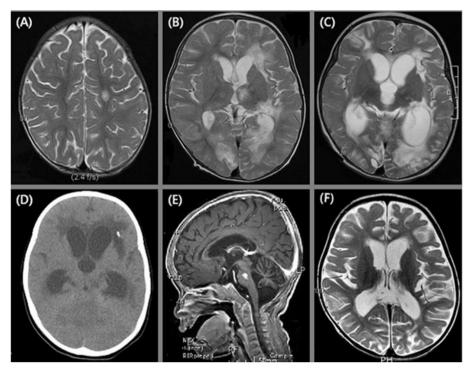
(A) At diagnosis, the MRI shows multifocal hyperintense leisions at the left temporal lobe and splenium of the corpus callosum. (B) At relapse, the MRI shows hydrocephalus and aggravation of the hyperintense lesions in both hemispheres and cerebellum, especially in the left basal ganglia, thalmus, brain stem and cerebellum. (C, D) Pretransplant brain MRI and CT show hydrocephalus and patchy hypersignal leisions in the periventricular and subcortical white matter of the cerebral and cerebellar hemispheres, and pons with small subcortical calcifications. (E, F) Five months post-transplant, the MRI shows nodular enhancing lesions in the brain stem, cerebellar hemispheres and both occipital lobes with improvement of the lesions noted previously.
